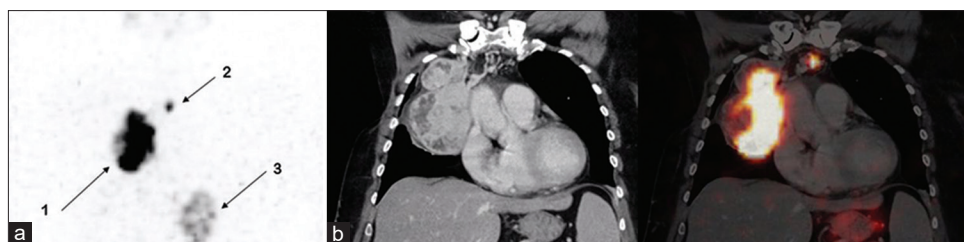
Images using 37 MBq (1 mCi) ^{123}I . (a) Maximum intensity projection visualizes accumulated activity in the intrathoracic thyroid tissue (arrow 1), in the smaller left-sided intrathoracic goiter (arrow 2) and in the stomach (arrow 3). (b) Computed tomography with intravenous contrast and fused images demonstrating significant tracer accumulation in the intrathoracic thyroid tissue
